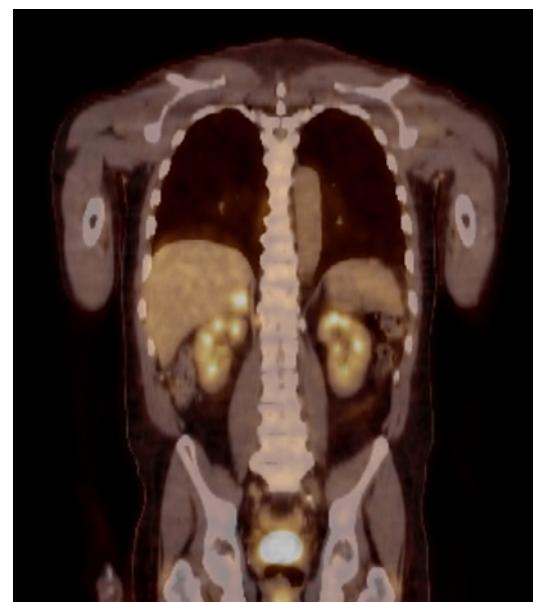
Coronal view of PET CT scan showing hypermetabolic activity in the right adrenal gland.
